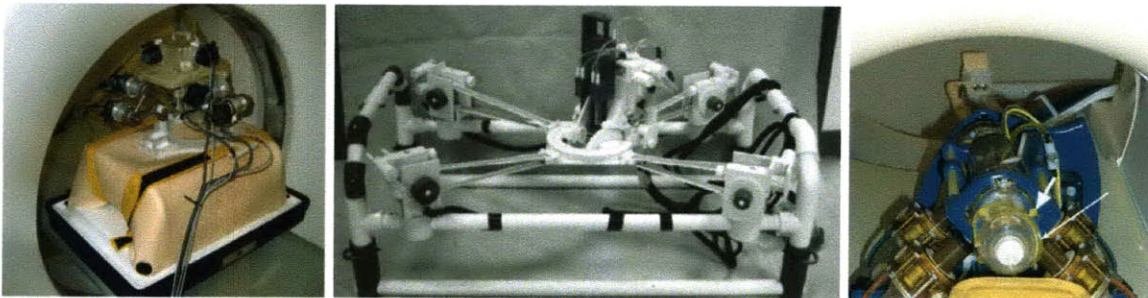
Image-guided robots that mount on the patient, over the patient or on the CT bed next to the patient. Left; the electromechanically driven CT-Bot has seven degrees of freedom and weighs approximately 7 kg [source (57)]. Middle; the light puncture robot (LPR) that is attached to a frame that rests over the patient as they lie on the scanner bed [source (61)]. Right; the pneumatic MrBOT from John's Hopkins University that is designed to accurately insert brachytherapy seeds into the prostate [source (59)].
